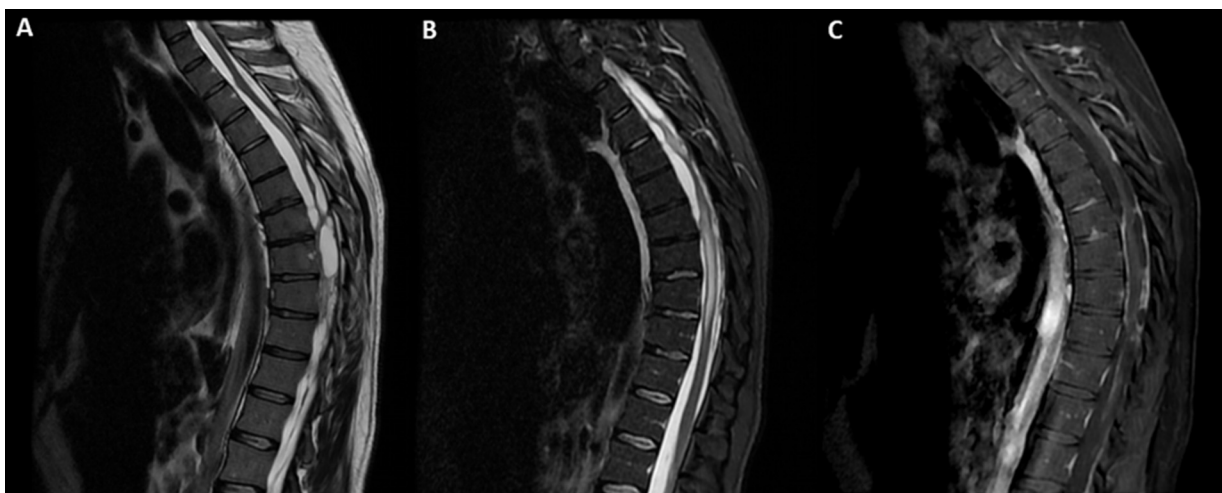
(A) Sagittal T2-weighted MRI showing septations in the subarachnoid space around the spinal cord; (B) sagittal short-tau inversion recovery (STIR) MRI showing hyperintensity and distortion in the spinal cord; (C) sagittal contrast-enhanced T1-weighted MRI revealing leptomeningeal enhancement around the entire spinal canal.
